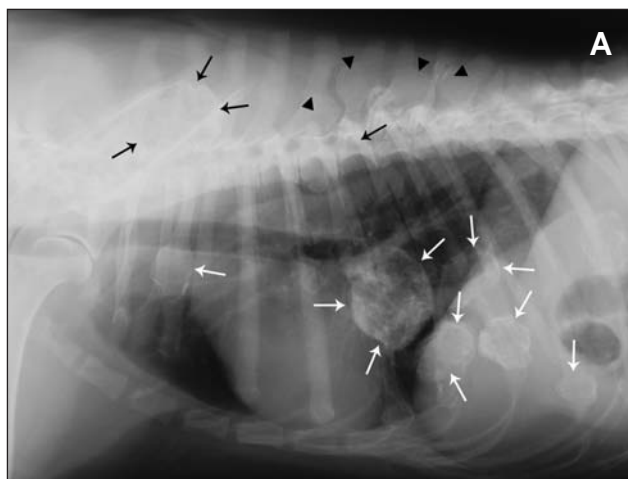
Same left lateral (A) and ventrodorsal (B) radiographic views as in Figure 1. Notice expansile osseous lesions (white arrows) originating from the sixth, seventh, and eighth ribs on the left side and the third, sixth, seventh, eighth, and ninth ribs on the right side of the thorax. A large lesion is evident at the level of the spinous processes at T2-T3, and a small lesion is evident at T7 (black arrows). Additional lesions are evident at the fifth, sixth, eighth, and ninth thoracic spinous processes (arrowheads).
